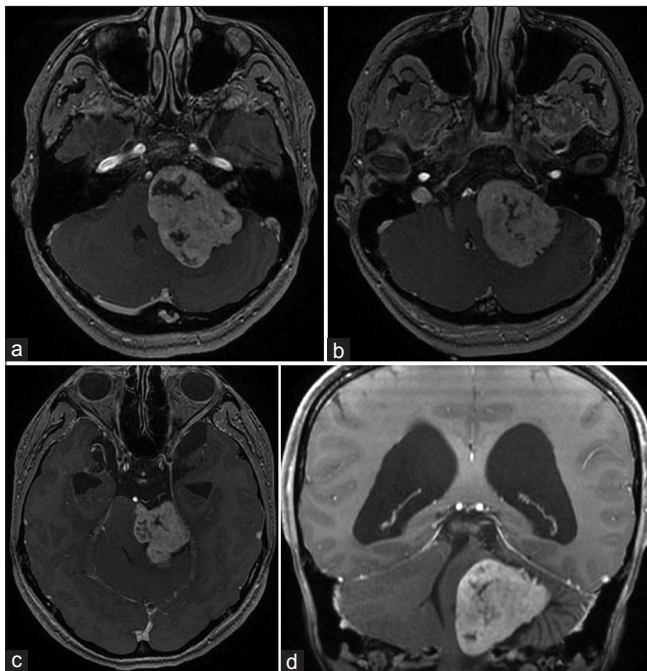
(a-d) T1-enhanced MRI demonstrating a 55 × 42 × 44 mm vestibular schwannoma and consecutive obstructive hydrocephalus in a 27-year-old woman presenting with headache, drowsiness, gait ataxia, and visual obscuration due to papilledema
